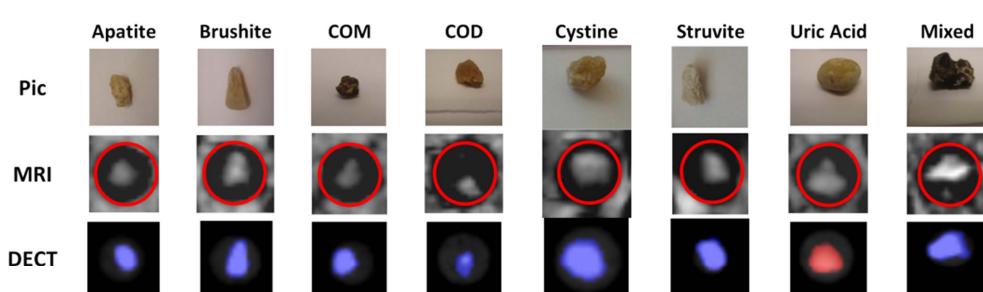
Different kidney stones (top) imaged with UTE MRI (middle) and DECT (bottom).
